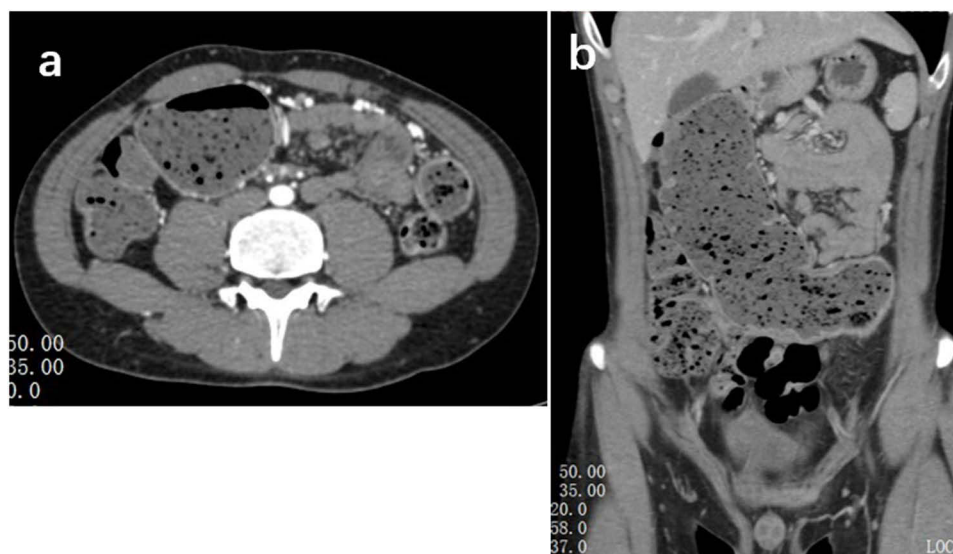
(a and b) Abdominal CT ascending colon, transverse colon, and part of the descending colon showing dilatation and fluid accumulation (most dilated at 5.2 cm).
